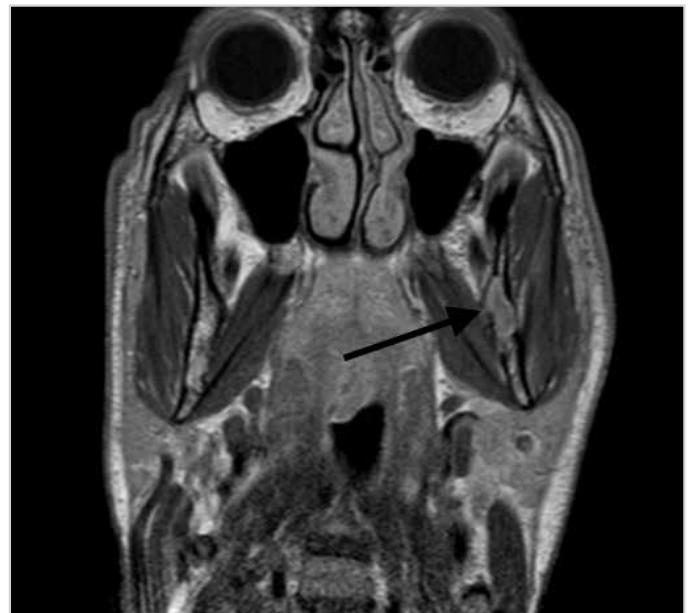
T1-contrasted coronal magnetic resonance imaging section showing a noninvasive cystic mass involving the ramus of the left mandible
